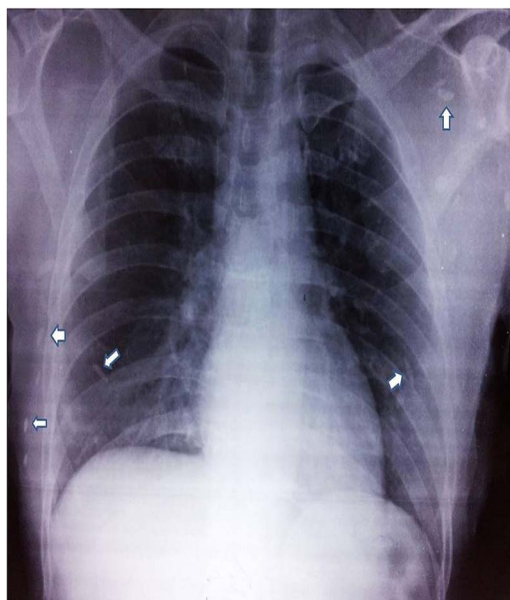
Chest radiograph showing typical 'rice-grain' or 'cigar-shaped' calcified lesions in the muscles of chest wall (white arrow).
